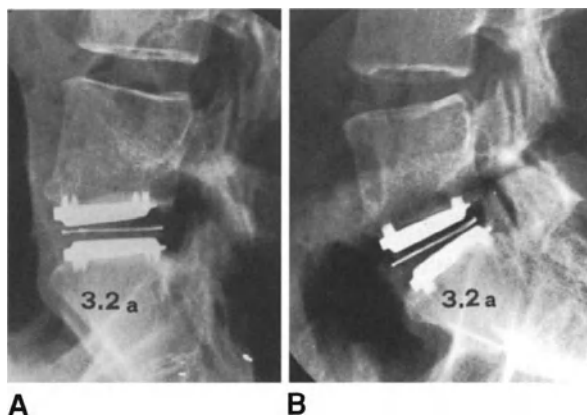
Flexion (A) and extension (B) radiographs in a patient who underwent disc prosthesis at L5-S1 level. The angular motion at the operated level is 13° .
